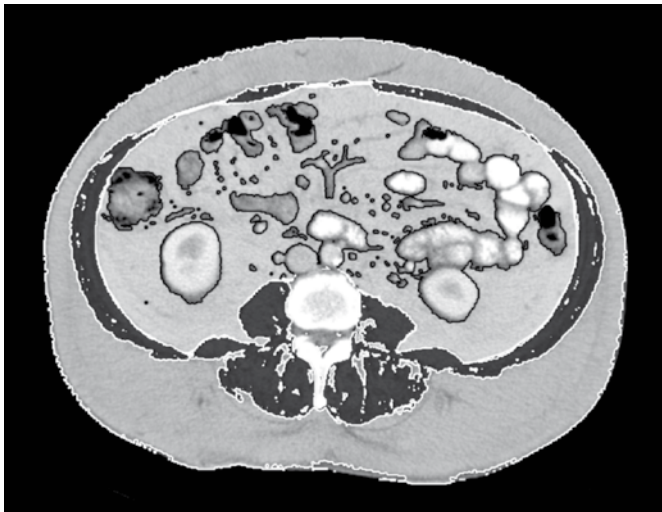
Segmented single slice CT-image showing different compartments of subcutaneous visceral adipose tissue, visceral adipose tissue and skeletal muscle mass
